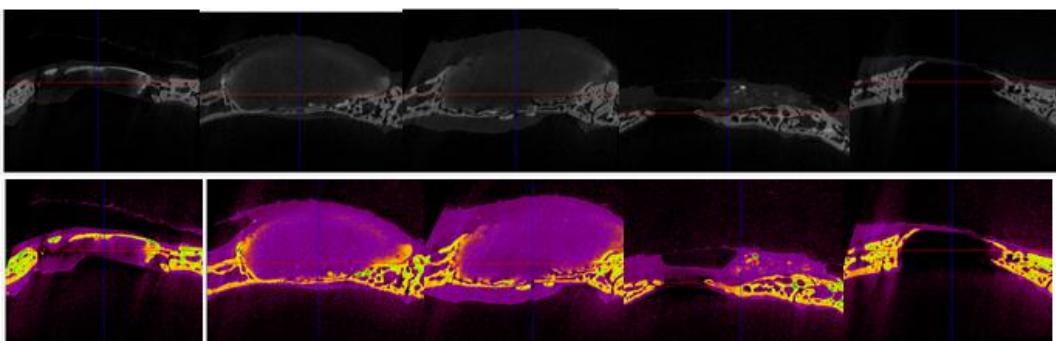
Micro CT images of hydrogel applied defects at 4 weeks. A. Hydrogel alone applied defect. B. Hydrogel+TAT-BMP-2 5 μ g applied defects.
